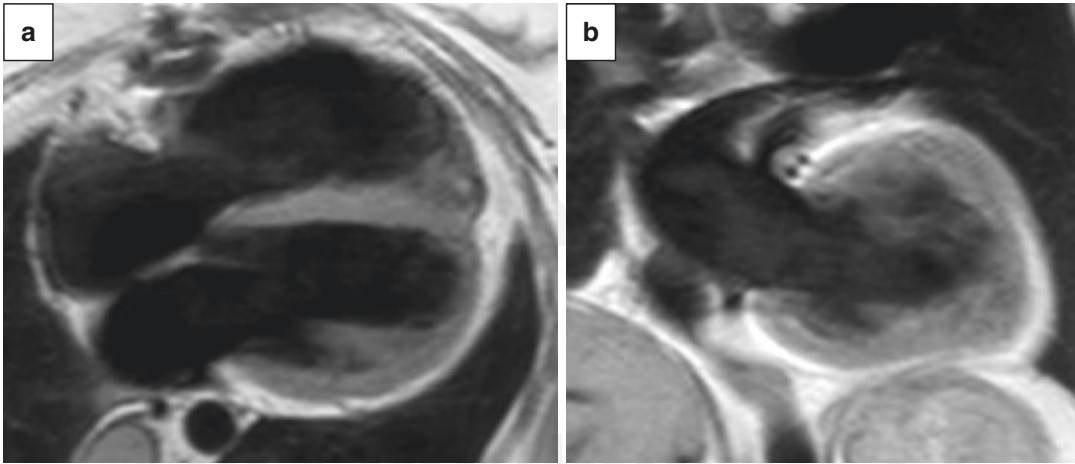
Same patient as in Fig. 10. MRI black blood (double IR FSE) images in axial view (a) and coronal view (b). Black blood sequences produce high-resolution, high-contrast static images
